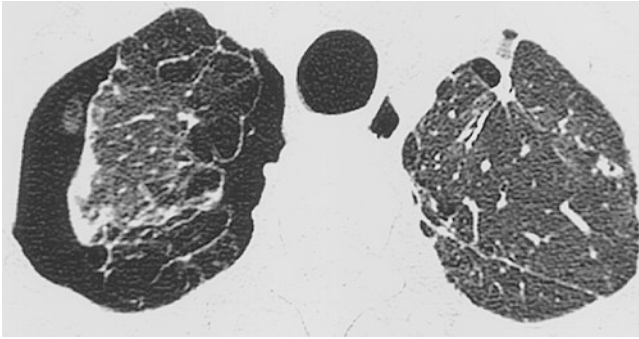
Patient with a spontaneous pneumothorax. On high-resolution computed tomography one finds an extensive emphysematous bulla in the right upper lobe
